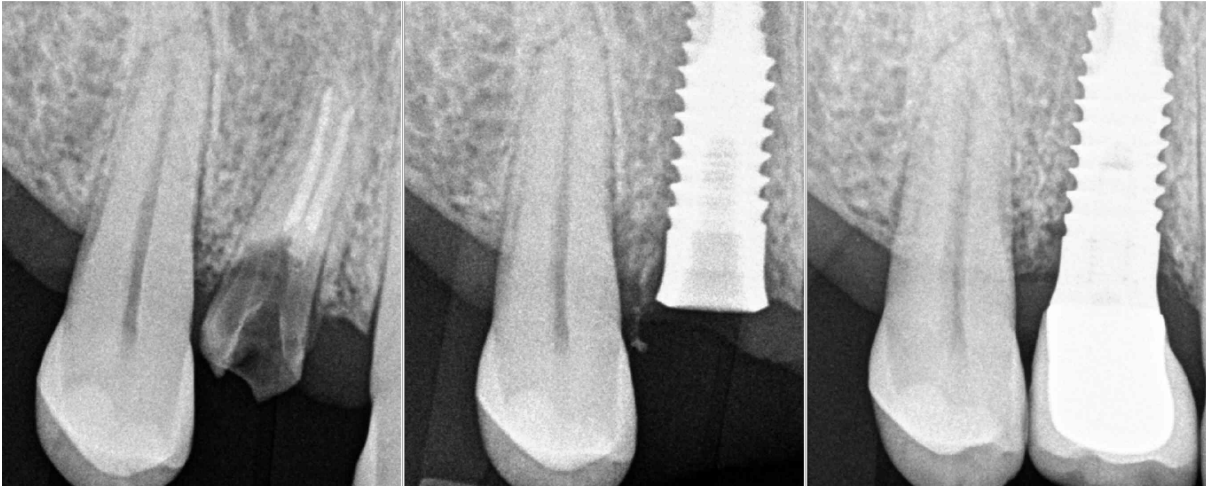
EXAMPLE OF RADIOGRAPHY OF THE CLINICAL STEPS FROM THE START TO THE CROWN IN FUNCTION
